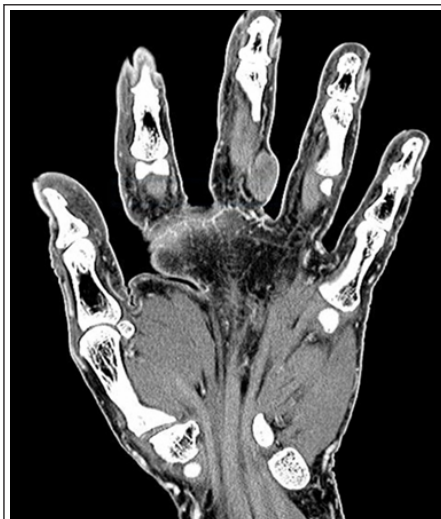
Coronal cut of computed tomography scan demonstrating mass in the long finger.
